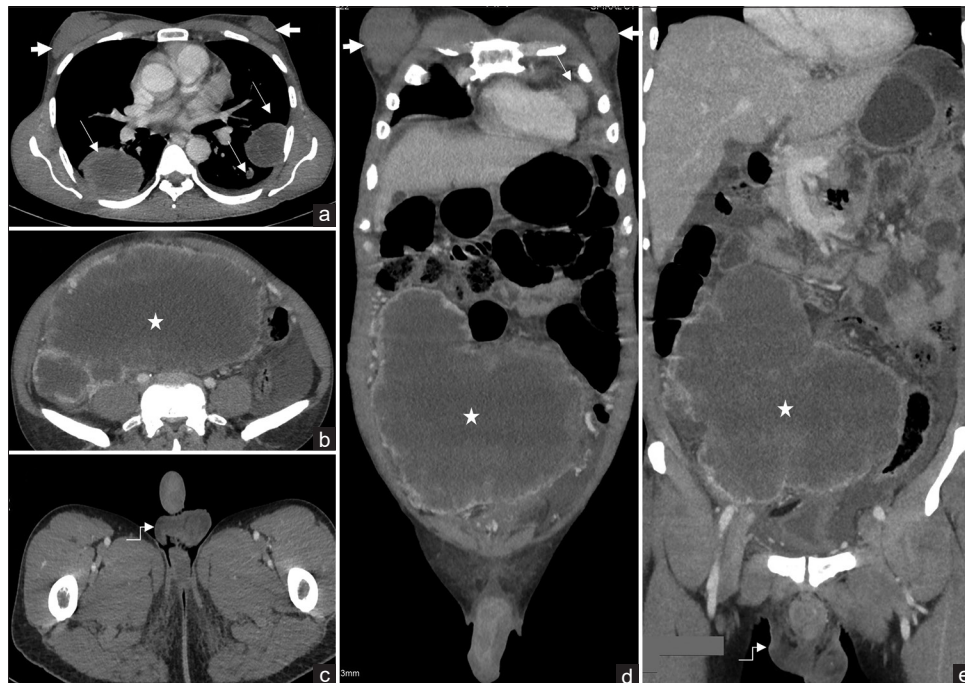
(a-e) Contrast-enhanced computed tomography axial and reformatted coronal images of the abdomen and chest reveal large lobulated peripherally enhancing soft-tissue attenuation mass with central necrosis (★) and multiple lung nodules (thin arrows) – biopsy-proven choriocarcinoma from an undescended testis with lung metastases. Bilateral gynecomastia (thick arrows) and empty right scrotal sac (elbow arrow) with a single left-sided testis are also seen
